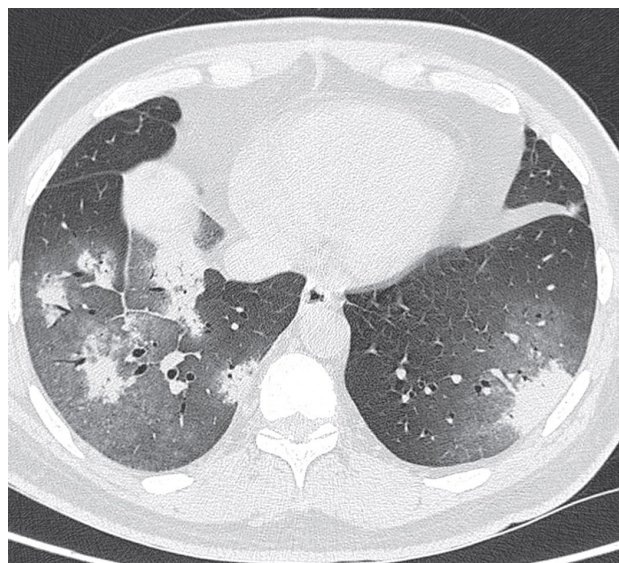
CT scan of chest showing post-COVID fibrosis. (COVID: coronavirus disease; CT: computed tomography)
